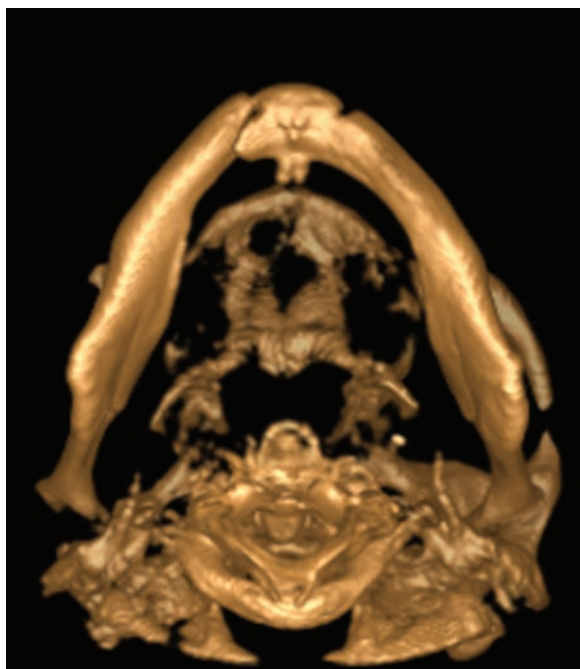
A cone-beam CT of an edentulous mandible reconstructed in a 3D format (and viewed from the under surface) showing a fracture in the right anterior zone. This occurred after implant placement, giving rise to considerable pain and infection. The implant was removed and the fracture required fixation with plates and screws.
